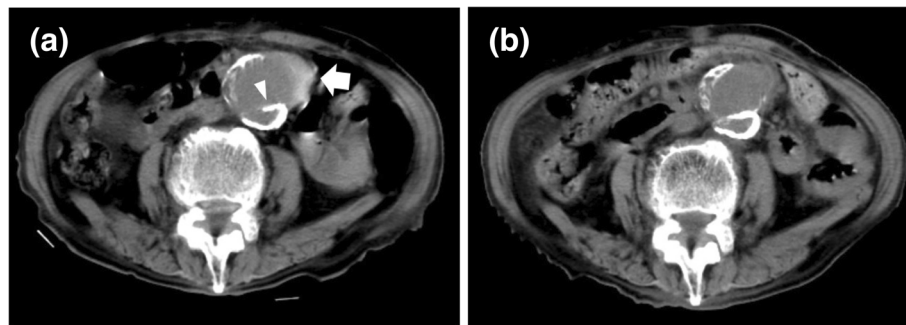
Images of unenhanced computed tomography (CT) at 1 (a) and 2 (b) months after the lumbar compression fracture. a Internal displacement of intimal calcifications (arrowhead) and a hyperattenuating crescent (arrow) are shown in the enlarged abdominal aorta. b The hyperattenuating fluid collection shows attenuation almost identical to that of intraluminal blood
